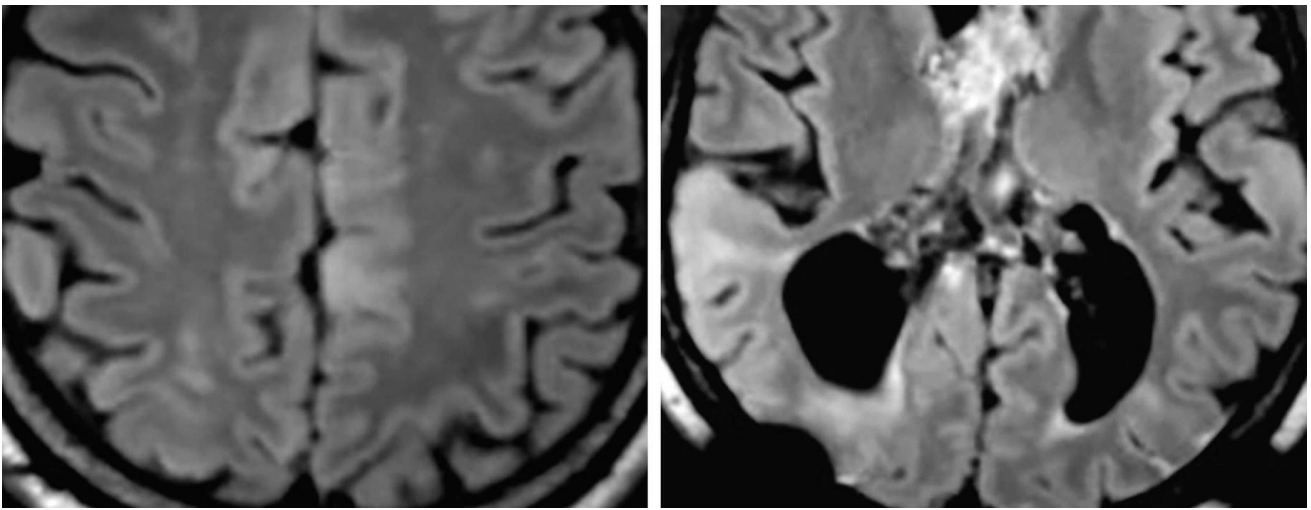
Multiple FLAIR-hyperintense (top left) subependymal nodules with corresponding dark susceptibility artifact (top right) that reflects calcification. (Middle Left) These nodules are also clearly visible in a T2-weighted image against the bright cerebrospinal fluid. (Middle Right) A few of the nodules demonstrate moderate enhancement. Note also the much larger heterogeneous lesion along the right lateral ventricle at the level of the caudothalamic groove compatible with a [SEGA](#). In addition, there are numerous regions of cortical expansion with T2/FLAIR-hyperintense signal (middle left and bottom left) and associated, increased linear signal radiating from the periventricular white matter to the subcortical regions (bottom right), known as the radial band sign.
